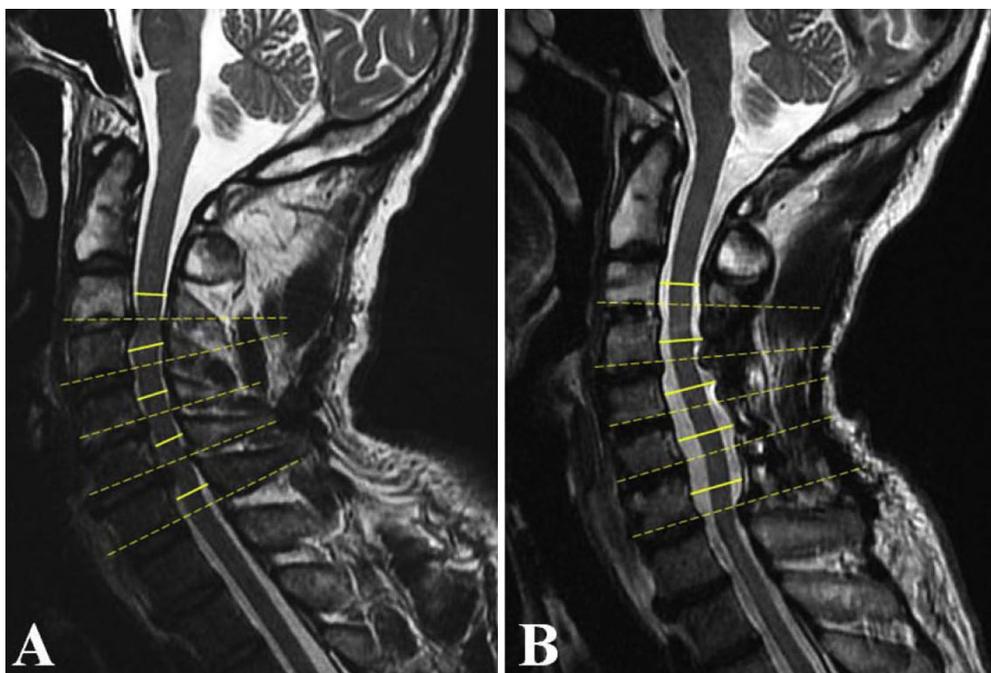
The anteroposterior dura diameter at each decompressed cervical level was measured using T2-weighted images preoperatively (A) and postoperatively (B).
